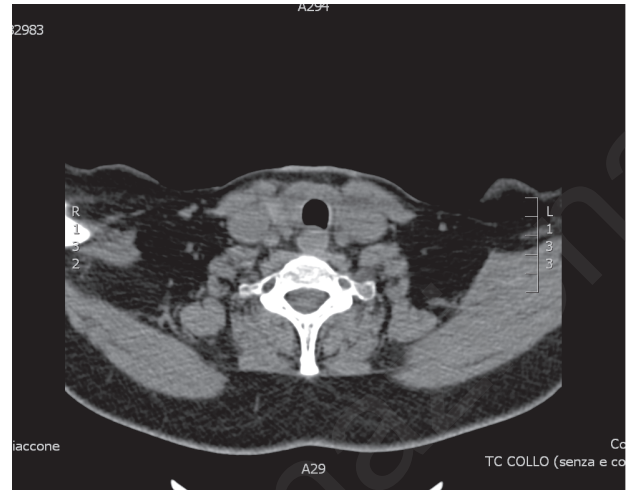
Total computed tomography one year after surgery.
